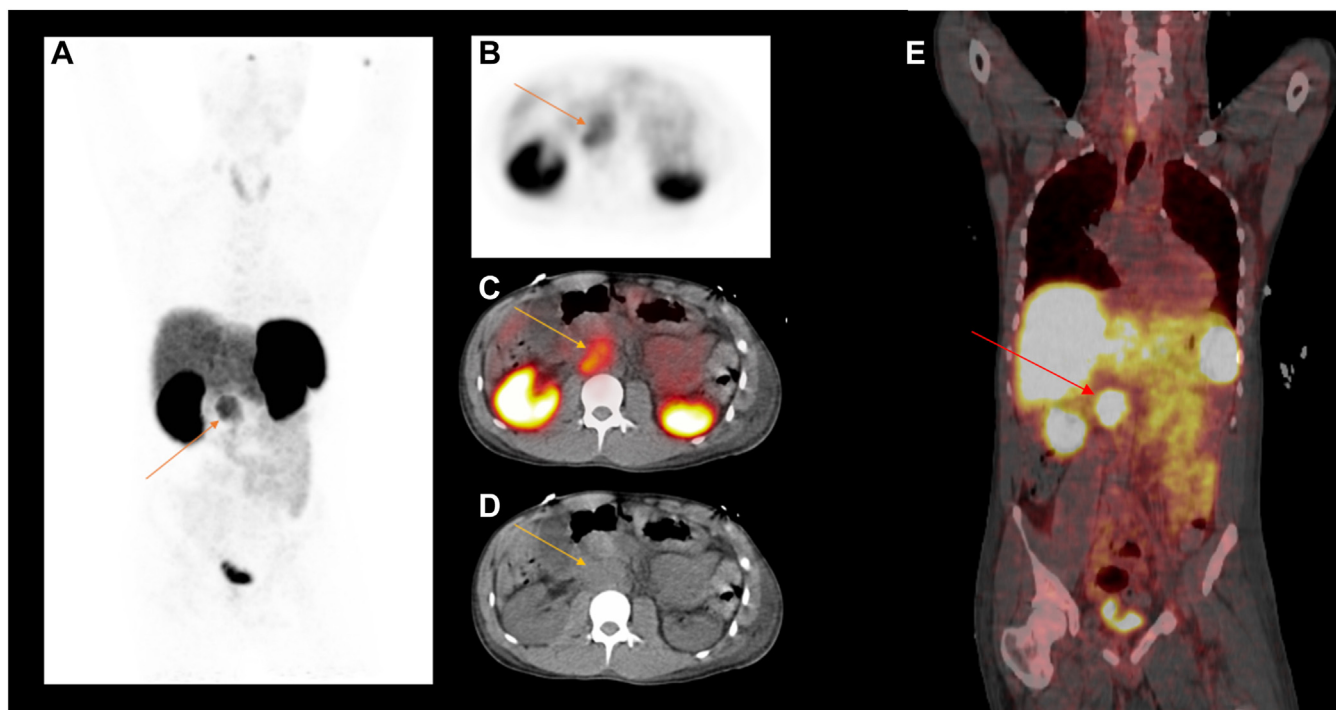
A, Maximal intensity projection of DOTATATE PET showing a single positive uptake corresponding to the aortocaval space mass; B, Axial view of DOTATATE PET at the level of the mass; C, Merged axial view of DOTATATE PET and CT; D, Axial view of CT at the level of the mass; and E, Coronal view of DOTATATE PET. Arrows: paraganglioma.
